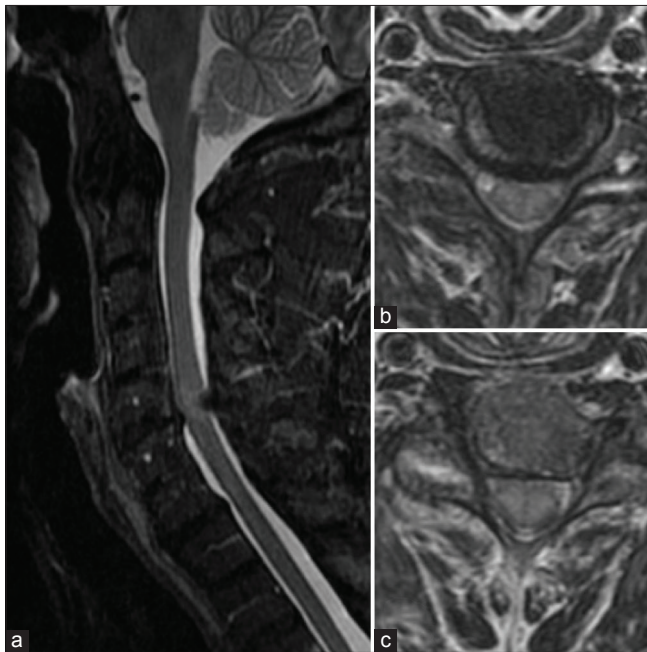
(a) The herniation of C5-C6, a suspicious traumatic lesion, and the C5-C6 compression by the thickened flavum ligament and posterior longitudinal ligament on the magnetic resonance imaging. (b) The reduced amplitude of spinal canal. (c) The spinal edema.
